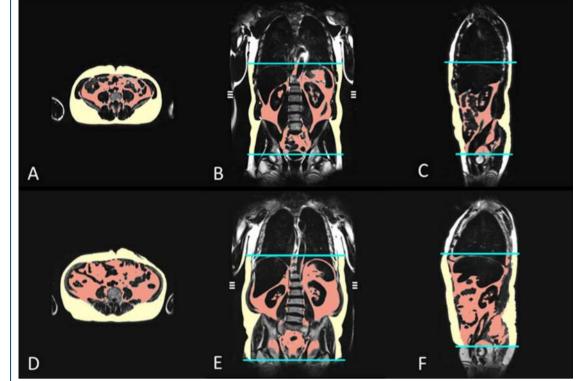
MRI-based assessment of adipose tissue depots in a 42-year-old male control (a-c);  $VAT_{volume}$  2.8 I,  $SAT_{volume}$  5.8 I,  $VAT_{area}$  89.8 cm<sup>2</sup>,  $SAT_{area}$  259.4 cm<sup>2</sup>) and an obese, 57-year-old male with prediabetes (d–f);  $VAT_{volume}$  9.1 I,  $SAT_{volume}$  10.8 I,  $VAT_{area}$  302.3 cm<sup>2</sup>,  $SAT_{area}$  332.2 cm<sup>2</sup>). The volumes of the different adipose tissue depots were measured automatically from the diaphragm to the femoral head by employing an in-house algorithm (b-c and e-f). VAT<sub>area</sub> and SAT<sub>area</sub> are derived from a single slice on the level of the umbilicus (a, d). (red area = VAT; yellow area = SAT). SAT, subcutaneous adipose tissue; VAT, visceral adipose tissue.
